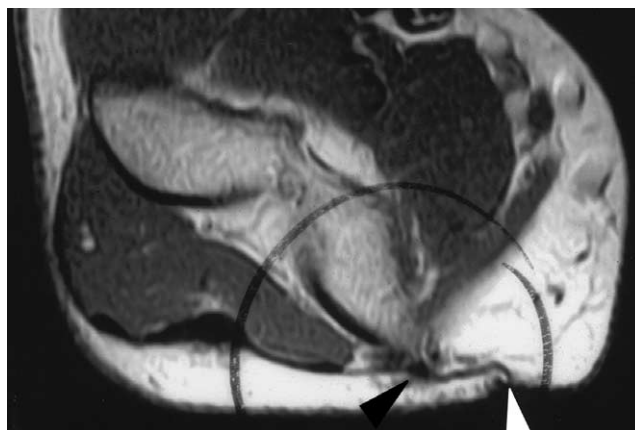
MRI of fascial band extending from a skin dimple (white arrow) to encapsulate the ulnar nerve (black arrow).
